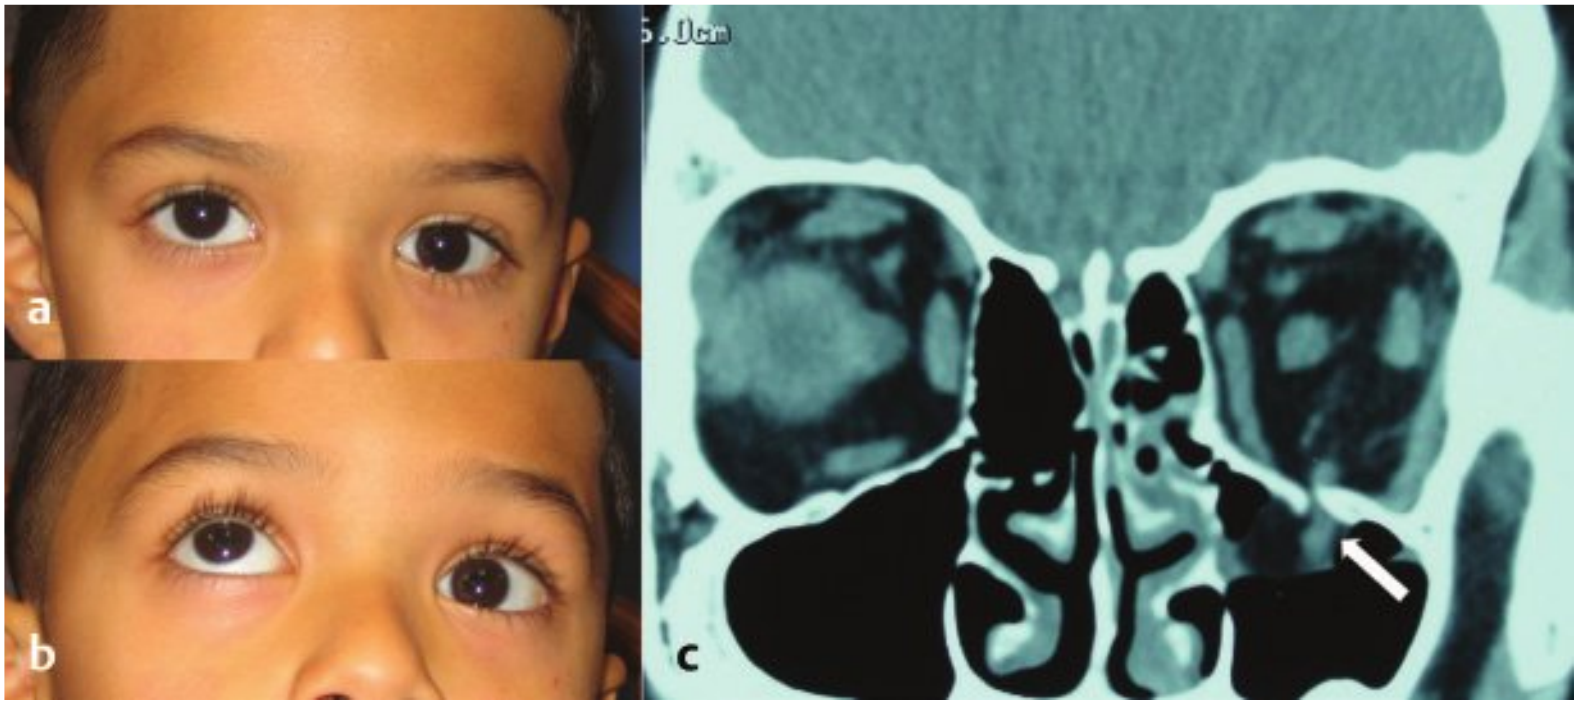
(a) Hypoglobus at rest. (b) Diplopia with upper gaze associated with entrapment of the inferior rectus muscle limiting ocular mobility. (c) Coronal CT scan; arrow indicates inferior rectus within the trapdoor of the fracture.
